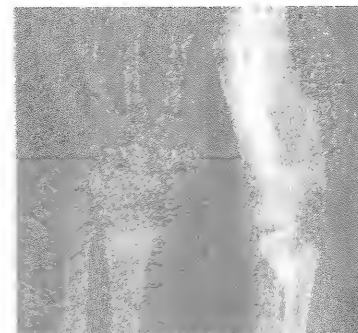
X-ray showing Colles' fracture.
